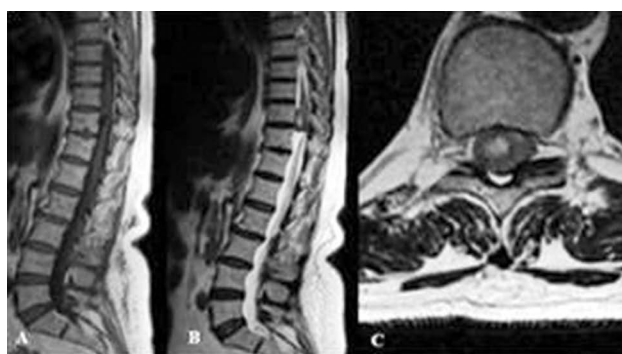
MRI of a schwannoma at the level of Th10-Th11: A) Sagittal view in T1 – isointense signal; B – C) Sagittal and axial views in T2 – moderate hyperintensity with a focal area with higher signal intensity.
